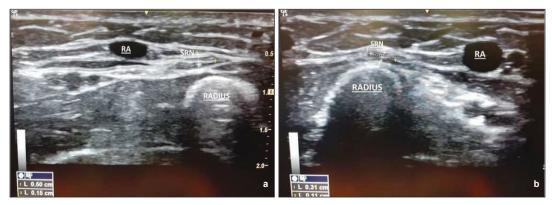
Sonographic evaluation of the superior branch of the radial nerve of the right (a) and left (b) forearm.
